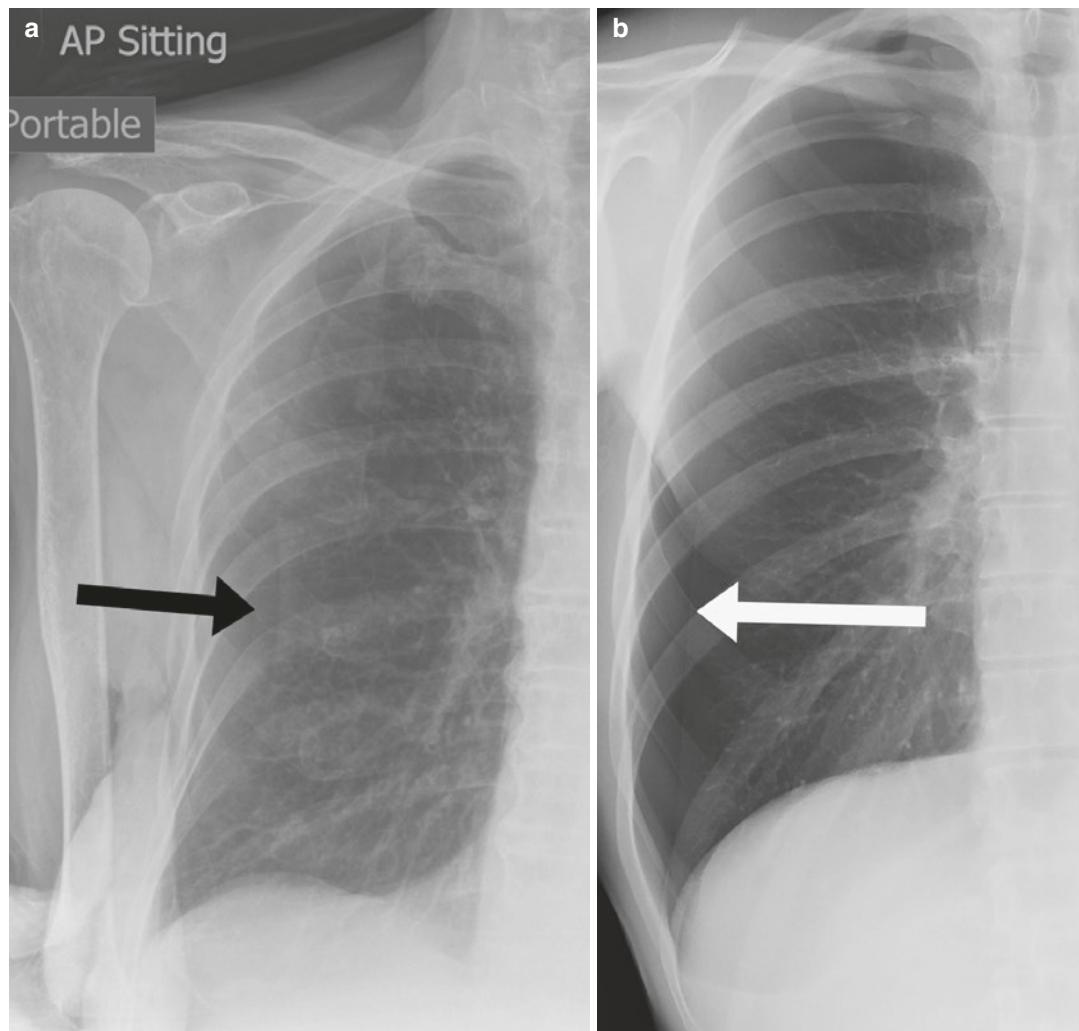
Skinfold versus pneumothorax. AP radiograph (a) demonstrates a curvilinear line in the right thorax secondary to a skinfold. Note the presence of subtle pulmonary vasculature markings peripheral to the line and the black outline immediate external to the line (black arrow).
